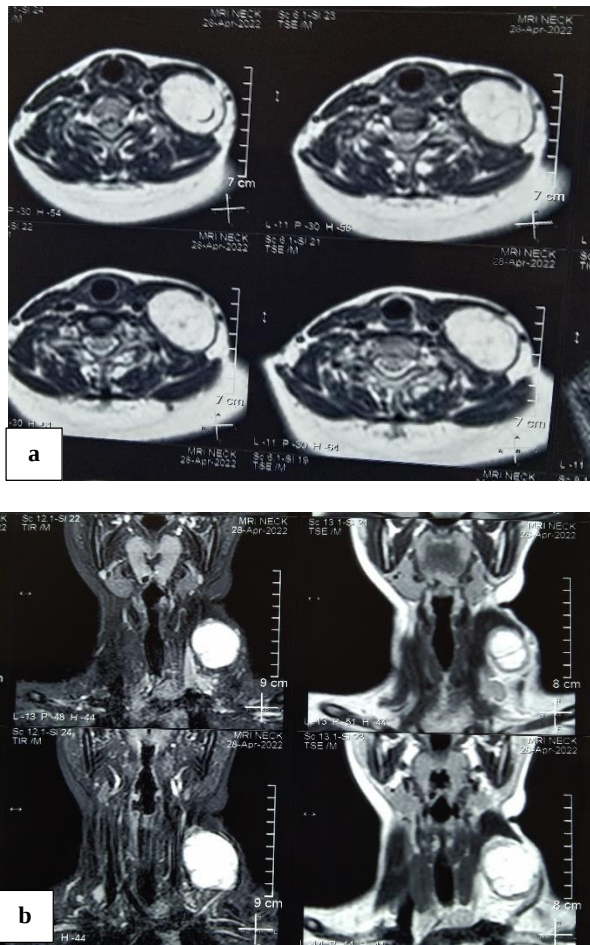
(a and b): MRI images of the neck in coronal and axial cuts showing well encapsulated mass with no vascular communication.
